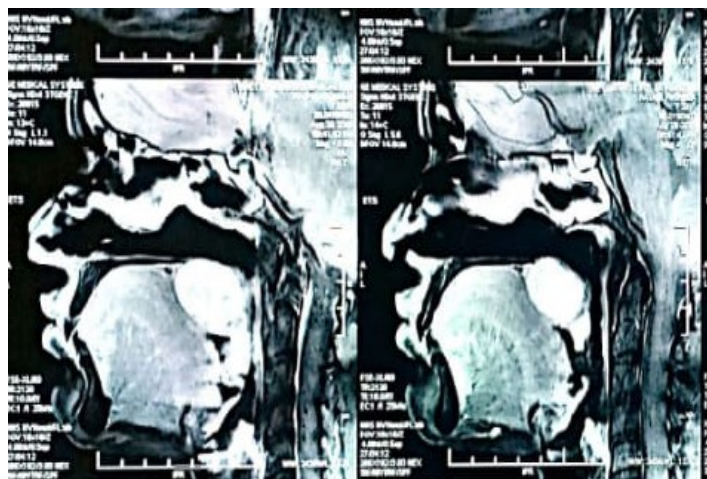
CT Revealing The extension of the Tumor
